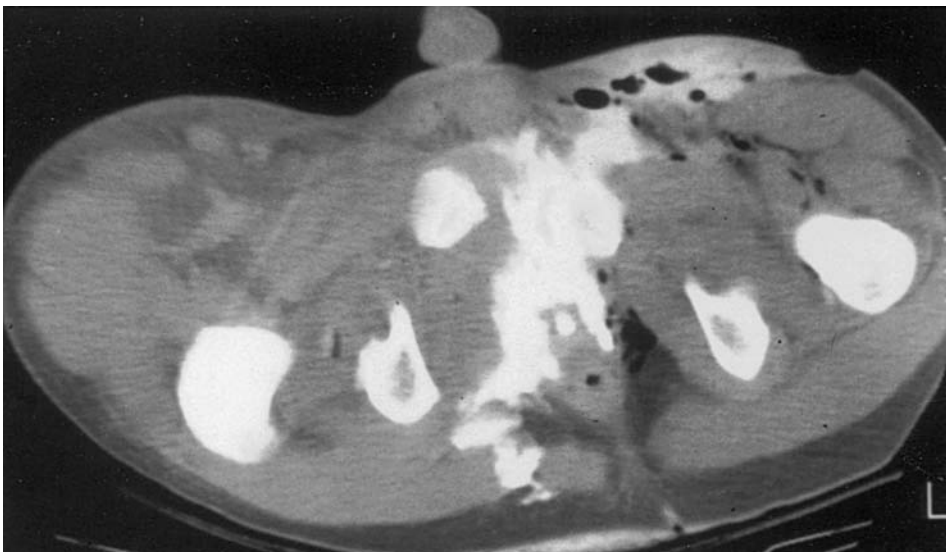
Posterior urethral disruption and pelvic fracture. Computed tomography of pelvis shows extravasation of contrast material from posterior urethra into the surrounding tissues.
